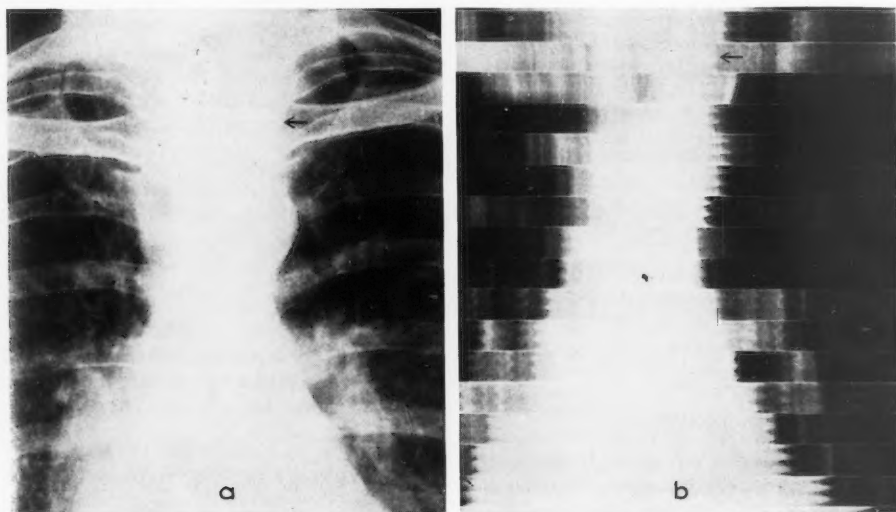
Coarctation in a 45 year old man. The aortic knob was prominent owing to ectasia. There was minimal widening of left brachiocephalic vessel shadow (a); pulsations were shown in the kymogram (b). (Roentgenograms courtesy of Dr. Harold O. Peterson.)
